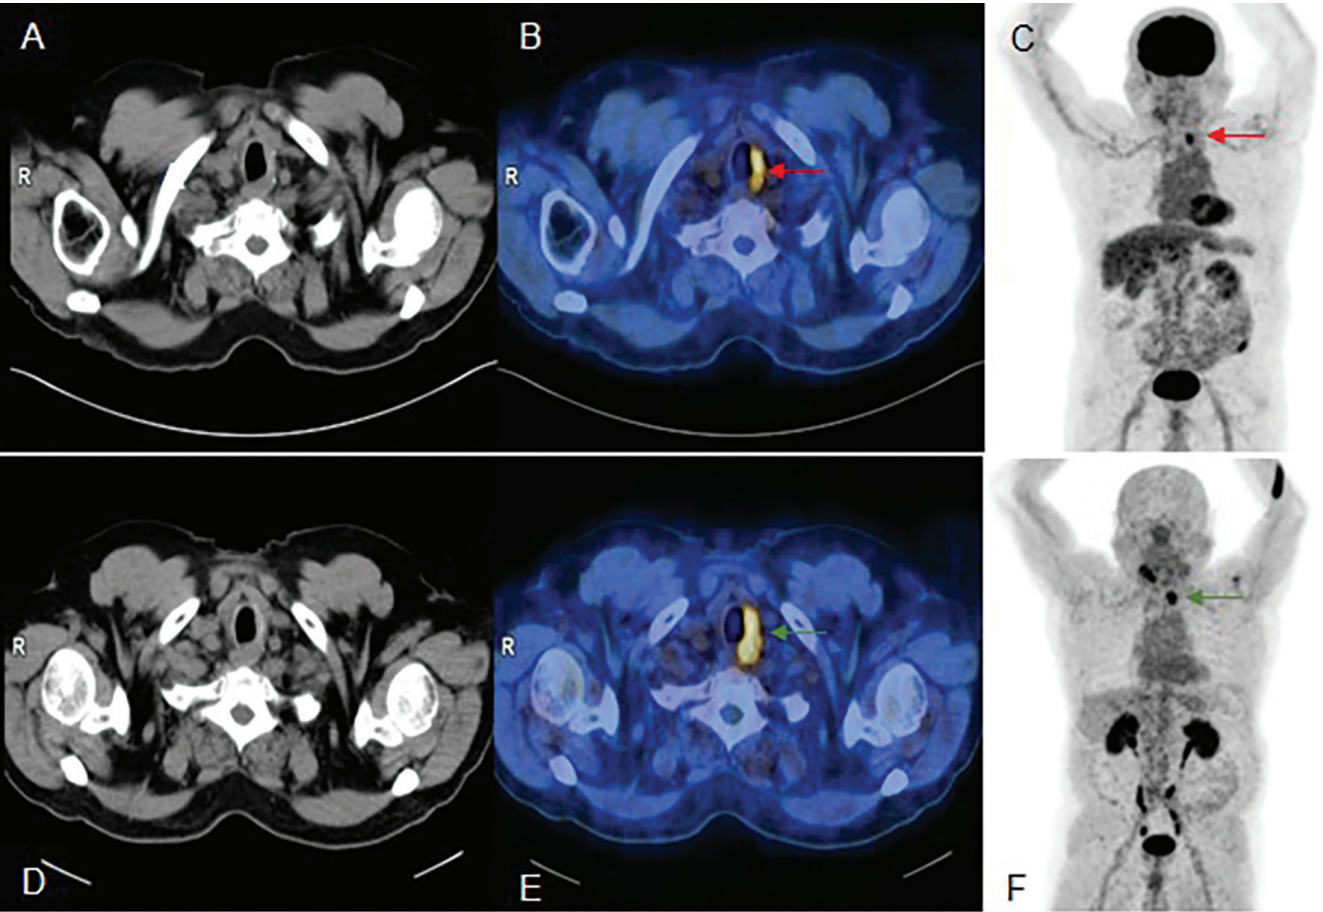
Detection of local recurrence in the thyroid bed. (A, D) axial non contrast CT shows an ill-defined soft-tissue lesion in thyroid bed on left side. (B) Selected axial fused images demonstrating moderate ¹⁸F-FDG uptake (SUV_{max}, 6.8) (red arrow). (E) ⁶⁸Ga-FAPI PET shows intense uptake (SUV_{max} 10.5) in the soft tissue lesion suggesting a prominent stromal reaction (green arrow). (C, F) MIP images of ¹⁸F-FDG PET and ⁶⁸Ga-FAPI PET Whole body PET showing focal increased ¹⁸F-FDG and ⁶⁸Ga-FAPI in lower neck and physiological tracer distribution in rest of the whole body
